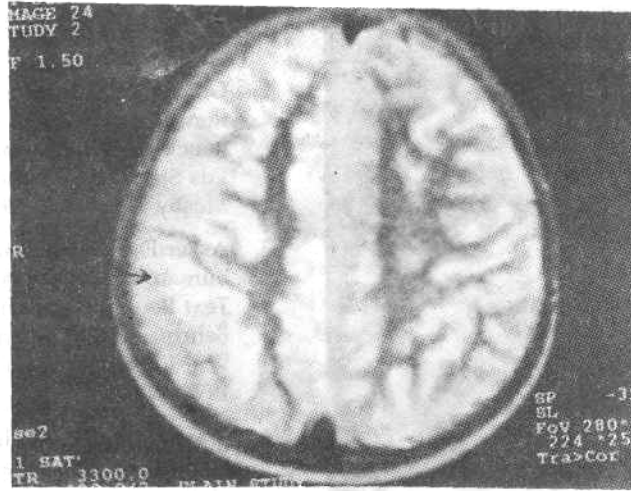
MRI showing multiple rounded lesions following the contours of gray white interface and showing outer scalloped margins in the right frontal parietal and occipital regions.
